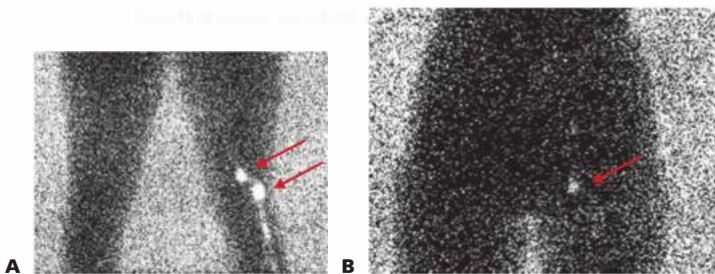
• Visualization of popliteal SLN. Lymphoscintigraphy of melanoma on the plantar surface of the calcaneus demonstrating both popliteal (A) and inguinal (B) SLNs (arrows) is shown.
